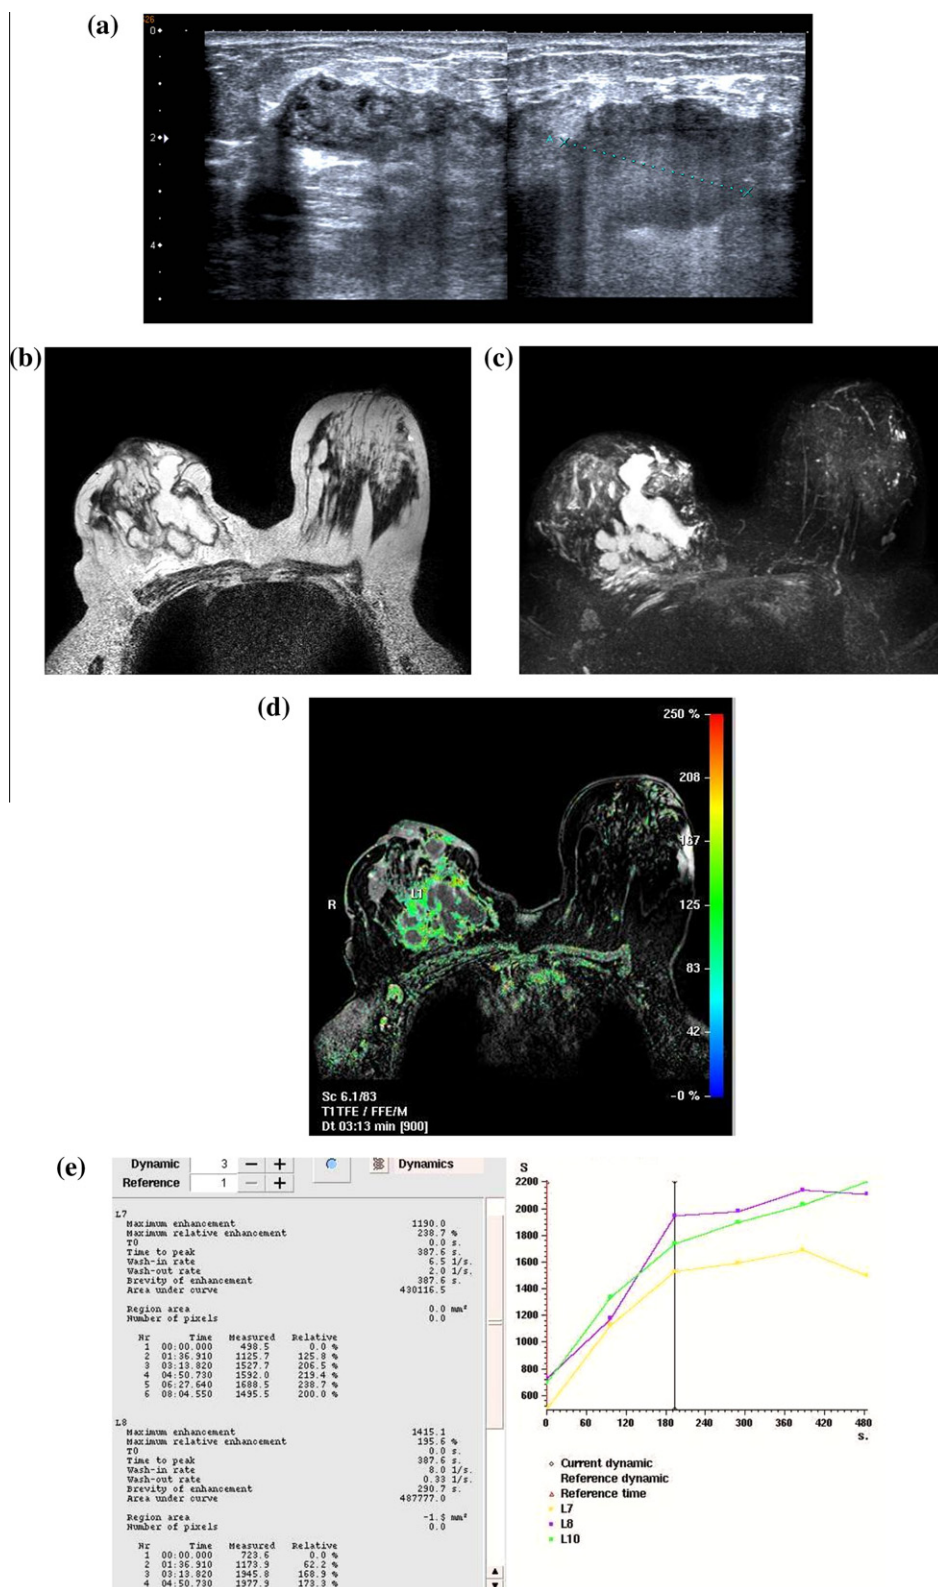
Right breast tuberculous abscess. (a) Gray-scale US image shows false impression of soft tissue infiltration. Axial (b) T2-weighted and (c) 3D MIP reconstructed T2 STIR show thick-walled multi-lobular cystic lesion of intermediate-high SI attributed to its turbid inspissated content. The entire extend of the right breast abscess as well as the ipsilateral enlarged axillary node can be easily seen in (c). (d) Axial THRIVE image 3.3 min post contrast with color overlay, shows intense marginal enhancement of the abscess cavity. (e) Time/SI analysis shows delayed peak of contrast uptake at 387sec. with corresponding SI% of 238–195% and type I (continuous rise) benign curve pattern.
